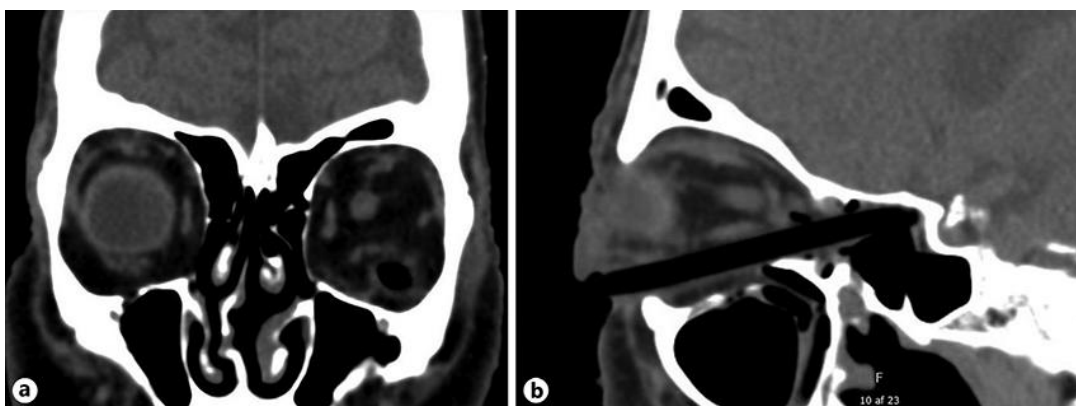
CT scans. A wooden foreign body penetrates the orbital region going into the sphenoid sinus. a Coronal view. b Sagittal view.
